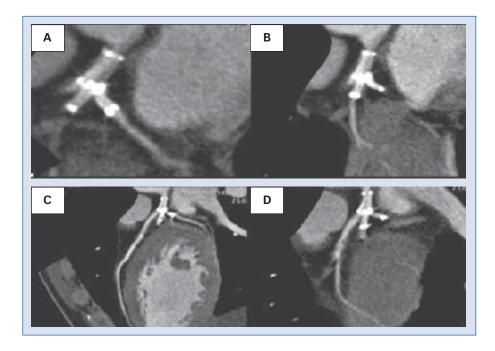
One month visit multislice computed tomography showed patency of all stents.
